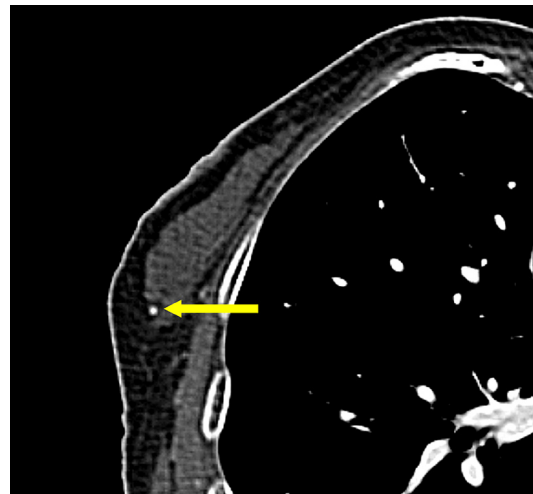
An axial CT imaging showing micro-calcification of the right breast (arrow), which is benign in nature. CT, computed tomography.
